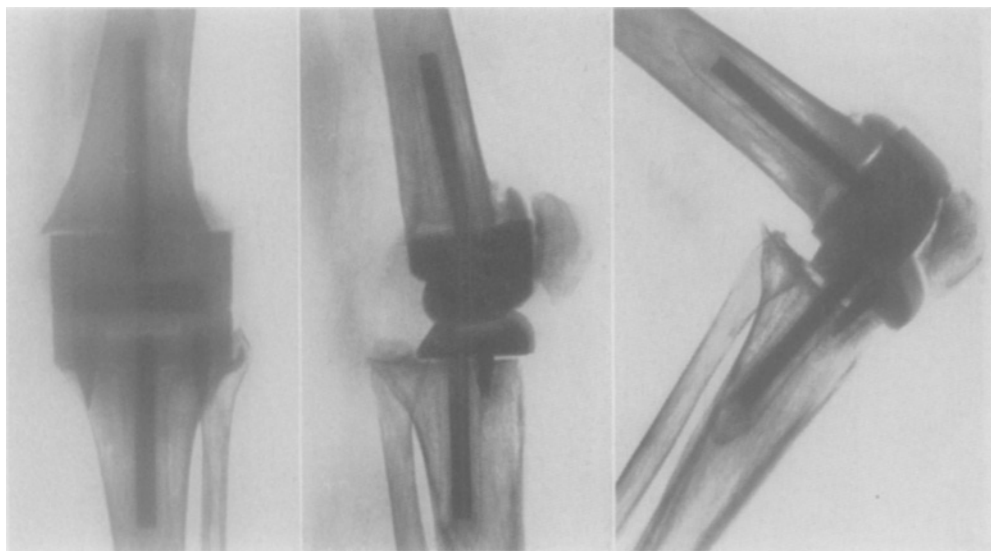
Case 8: roentgenograms of left knee 2 years after arthroplasty.
